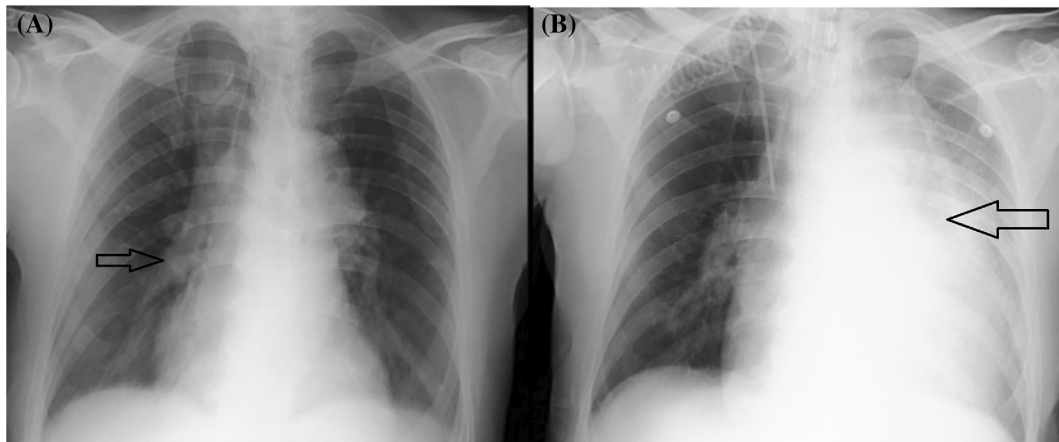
(A) Chest radiograph at admission showing enlarged right descending pulmonary artery; (B) Chest radiograph 48 h after thrombolysis showing in homogenous opacity in the left perihilar region with mediastinal widening.
